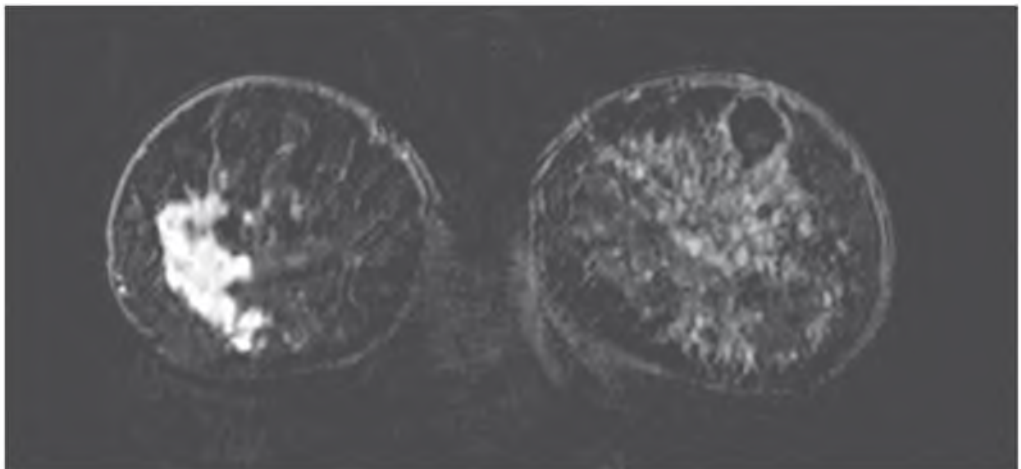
A large mass on a subtracted high resolution MR image in a right breast representing a very large ILC, note the long spiculae at the superior margins of the tumour suggesting linear spread along the ductuli.
